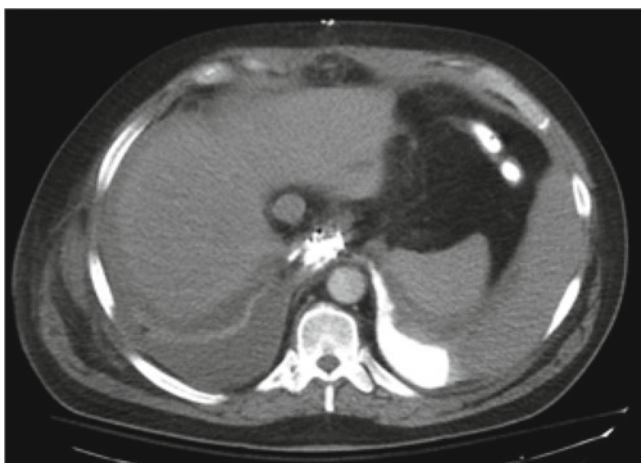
CT scan of an intrathoracic anastomotic leak after esophagectomy resulting in left pleural contamination
